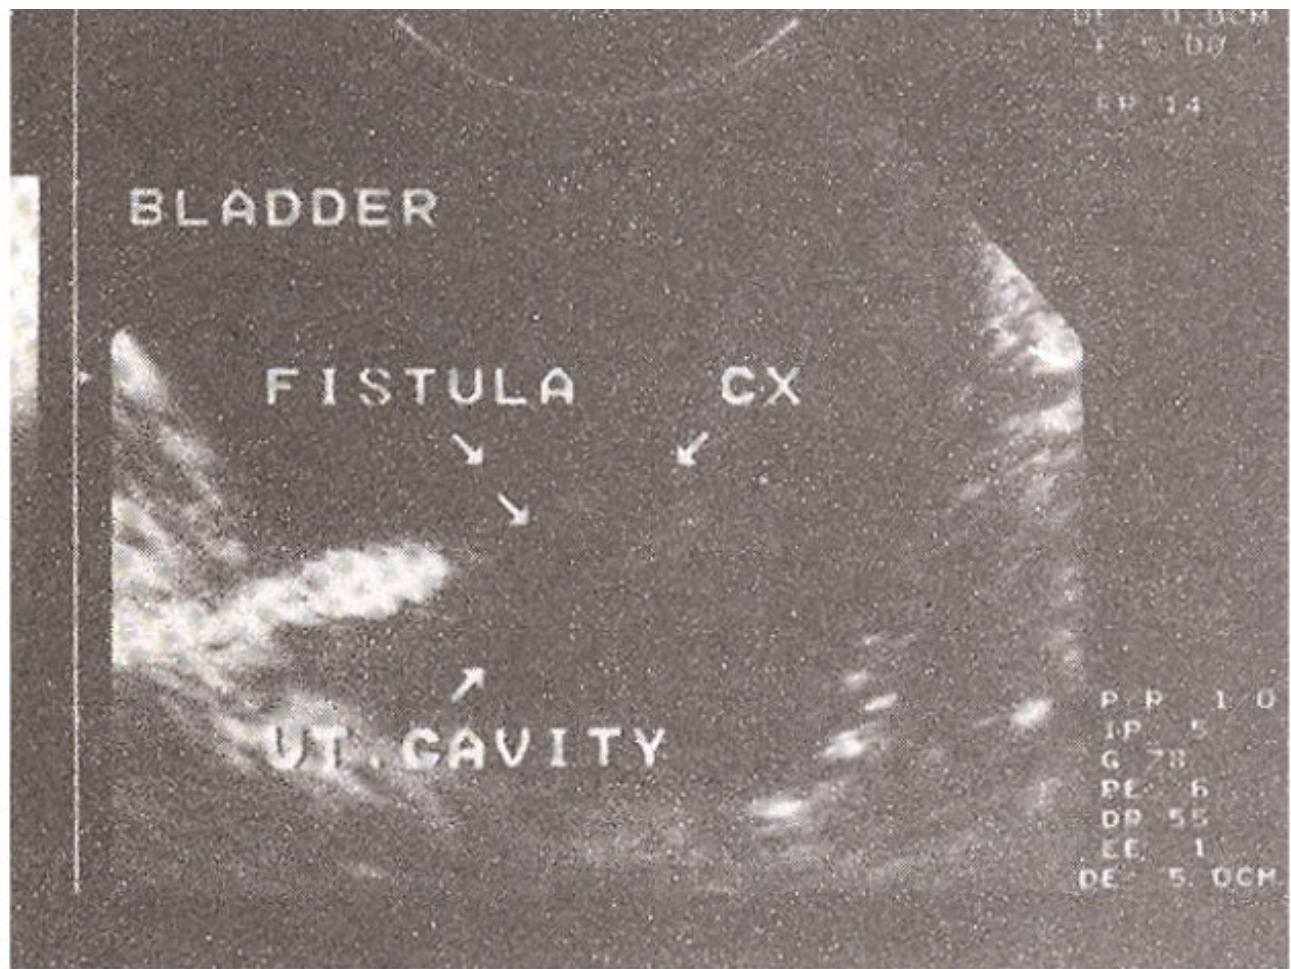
Ultrasound scan showing a fistula between the bladder and uterus above the level of the internal os.
